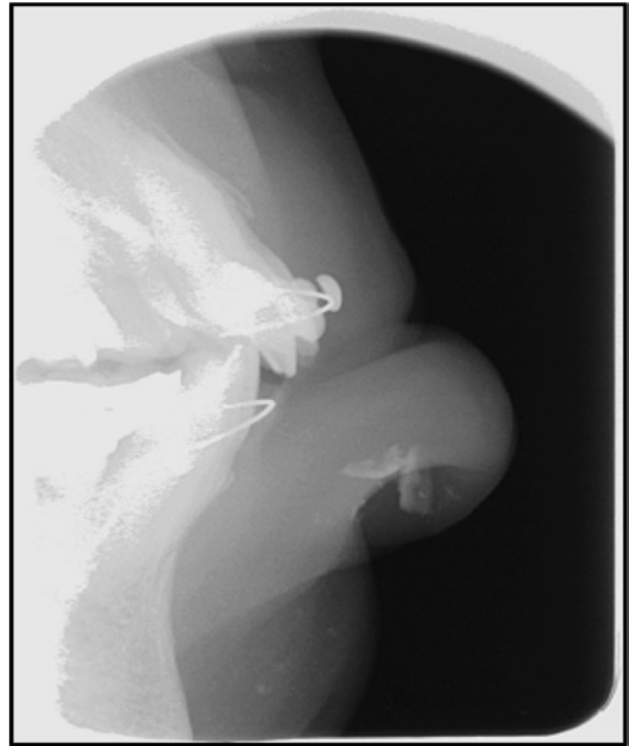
Soft tissue radiograph showing embedded tooth fragments in the lower lip.
